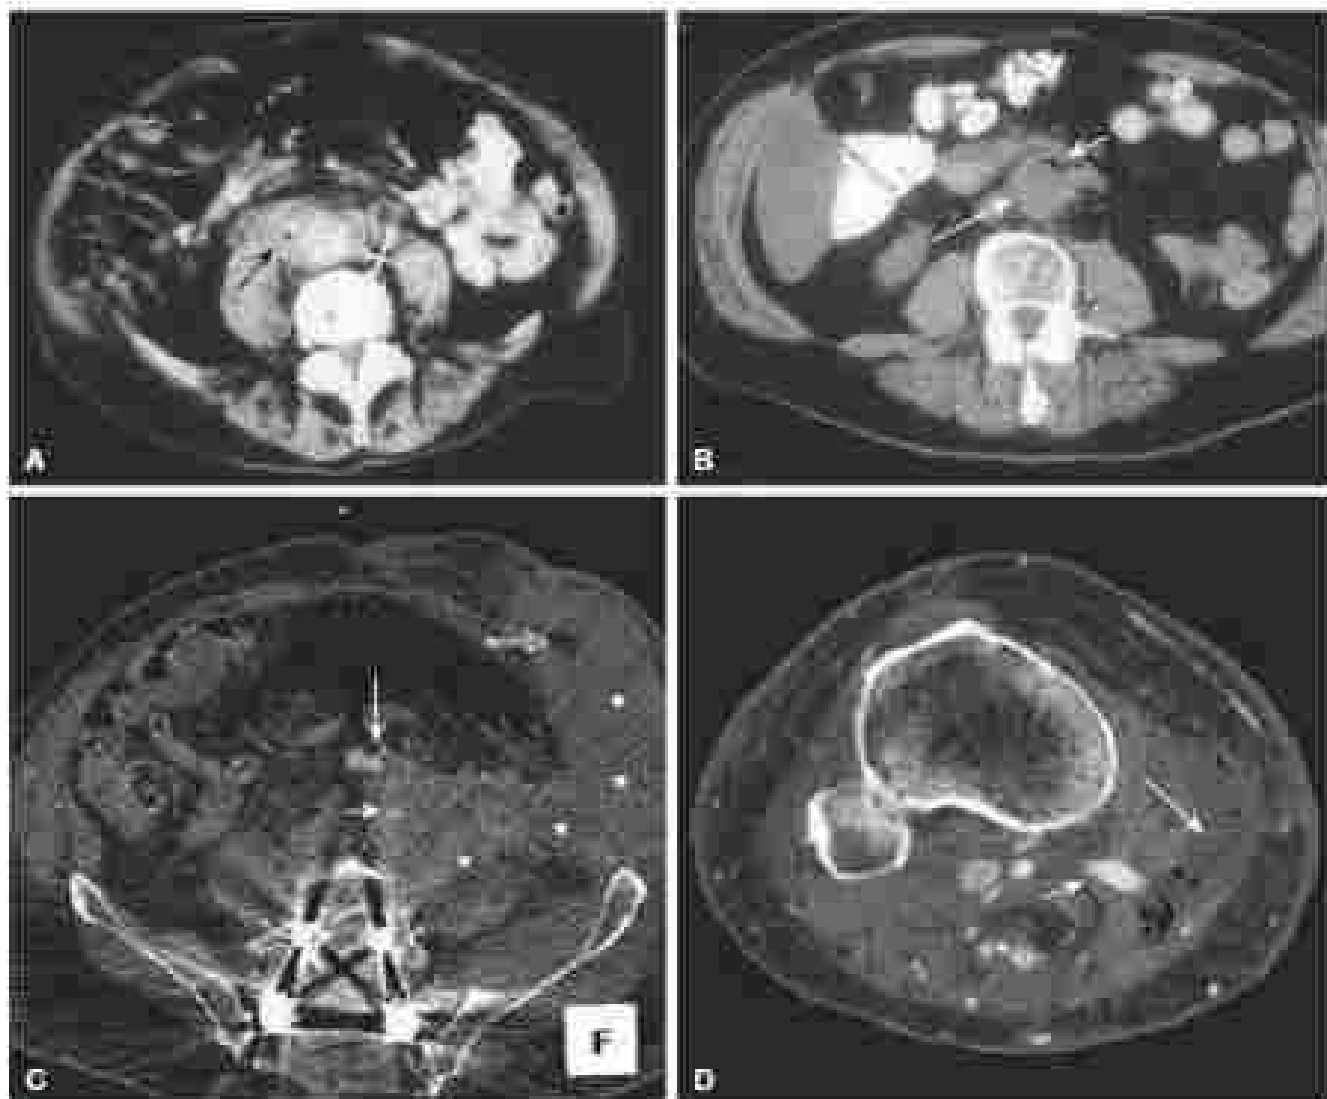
Computed tomography images demonstrating vascular graft anastomosis. (A) Perigraft fluid. (B) Thickened perigraft tissue and air within the graft and perigraft tissue. (C) Pericatheterization of graft with anastomosis. (D) Air and contrast in the retroperitoneum level (large arrow), patent graft anastomosis (small arrow). (E) Axial CT scan of the perigraft anastomosis. (Courtesy, American College of Interventional Radiology and Endovascular Surgery, <http://www.acir.org>, 2007.)
